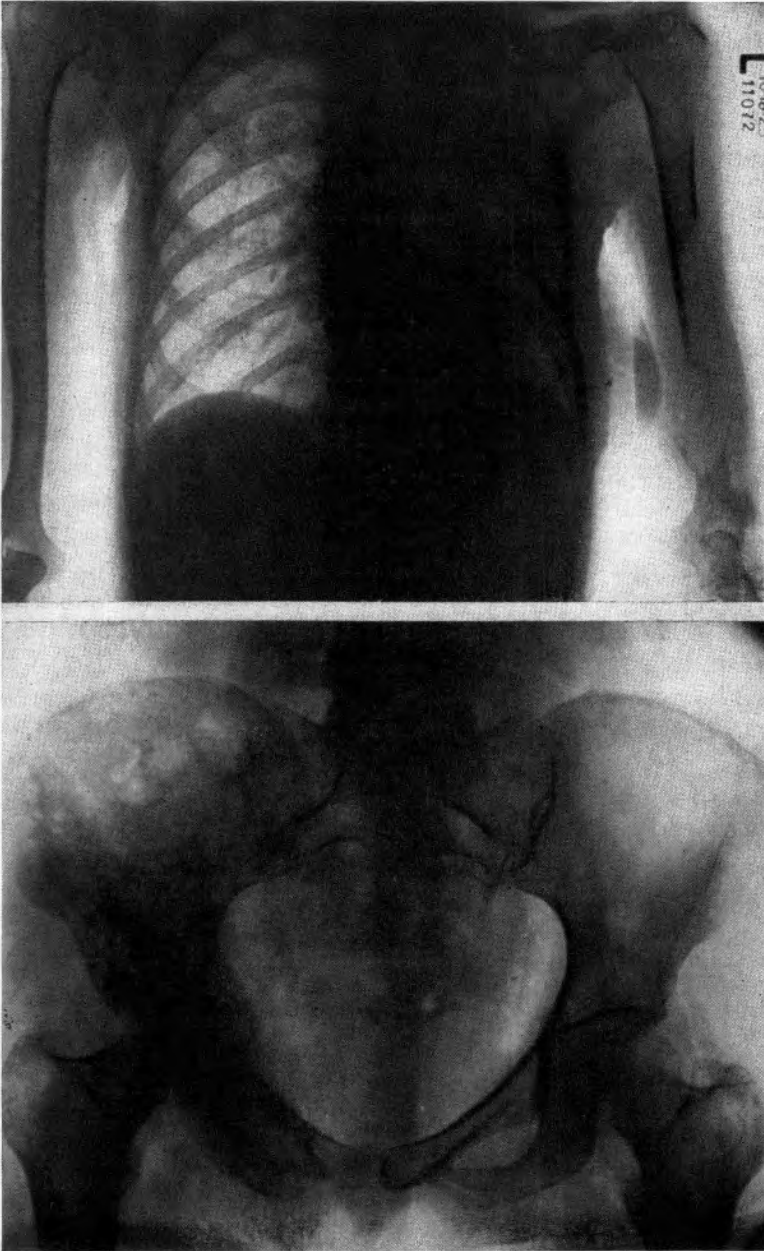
Roentgenograms of osseous metastasis in mammary cancer. Both bone destruction and new bone formation are seen in the left humerus and right pelvis.
